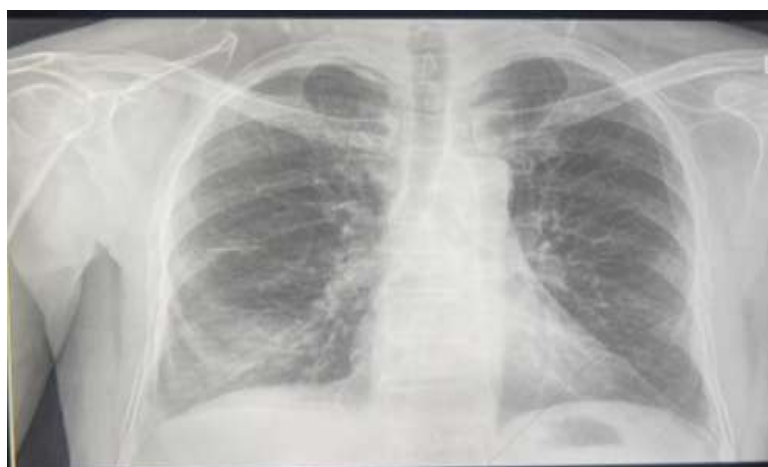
Chest radiograph showing right lower zone consolidatory changes.
